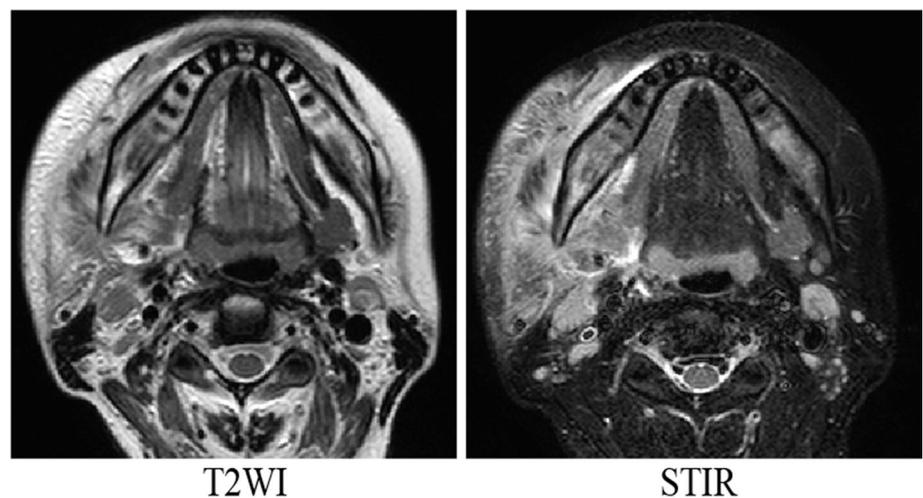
Magnetic resonance imaging of inflammation in the right cheek. In the T2-weighted image, fatty tissue and water-based tissue are both depicted as having high signals. Therefore, the range of inflammation is difficult to determine. Because short-TI inversion recovery cancels the signal from fatty tissue, the range of inflammation is easy to ascertain
